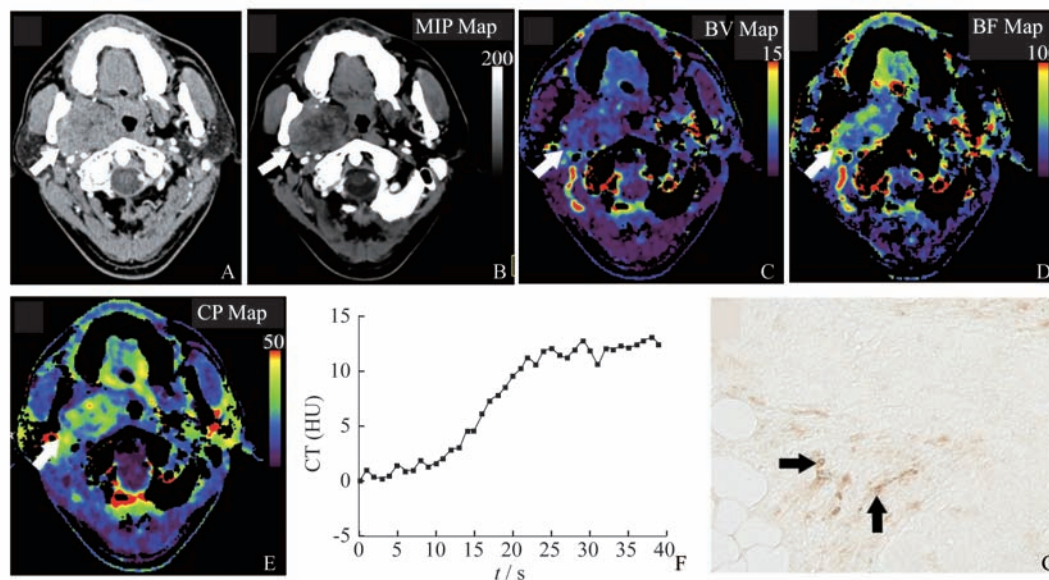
A 组多形性腺瘤的 CT 灌注伪彩图及微血管染色结果
